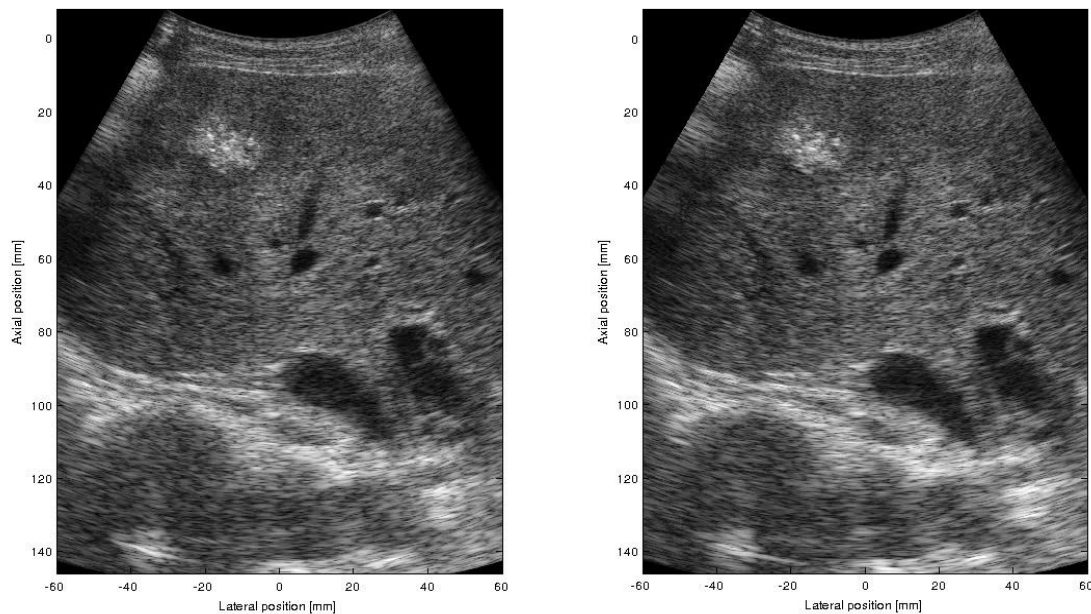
Recording of liver tissue with a tumor. The images are the interleaved recordings with SASB on the left and conventional ultrasound on the right.
